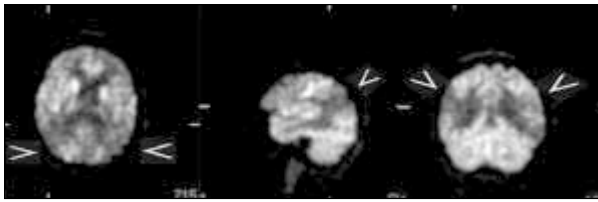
Transaxial, sagittal and coronal FDG PET images in a patient with Alzheimer's Disease showing bilateral temporo-parietal defects (arrows). Images courtesy of Abass Alavi, MD, Hospital of the University of Pennsylvania.
